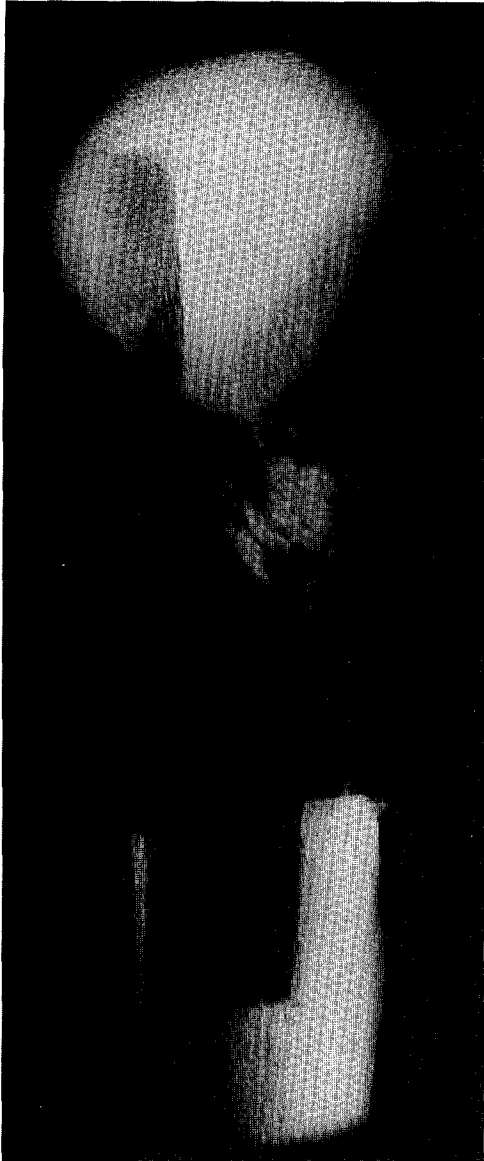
Radiograph of heterotopic bone within allograft.
